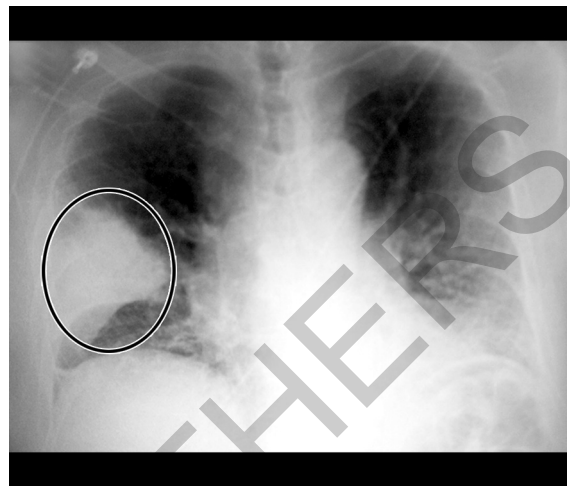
Chest X-ray—increased opacity (whiter in appearance), increased lung density.
